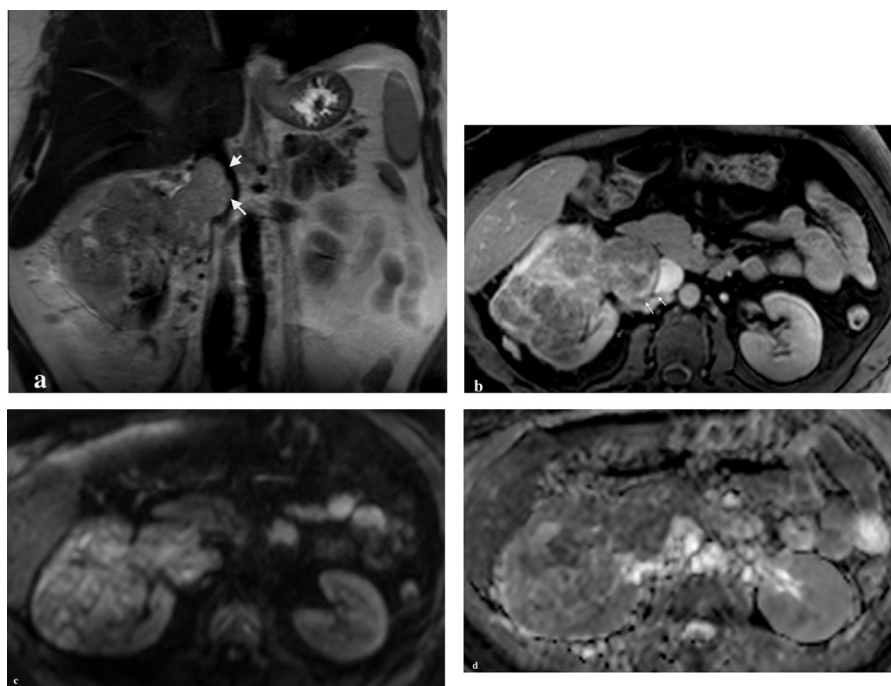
A 52-year-old female with clear cell RCC. (a) Coronal T2WIs and (b) Postcontrast axial T1WIs show large right renal mass invading the RV and IVC (arrows), (c) DWI at b value of 800 and (d) ADC map show restricted diffusion of the lesion, and the ADC is $1.5 \times 10^{-3} \text{ mm}^2/\text{sec}$.
